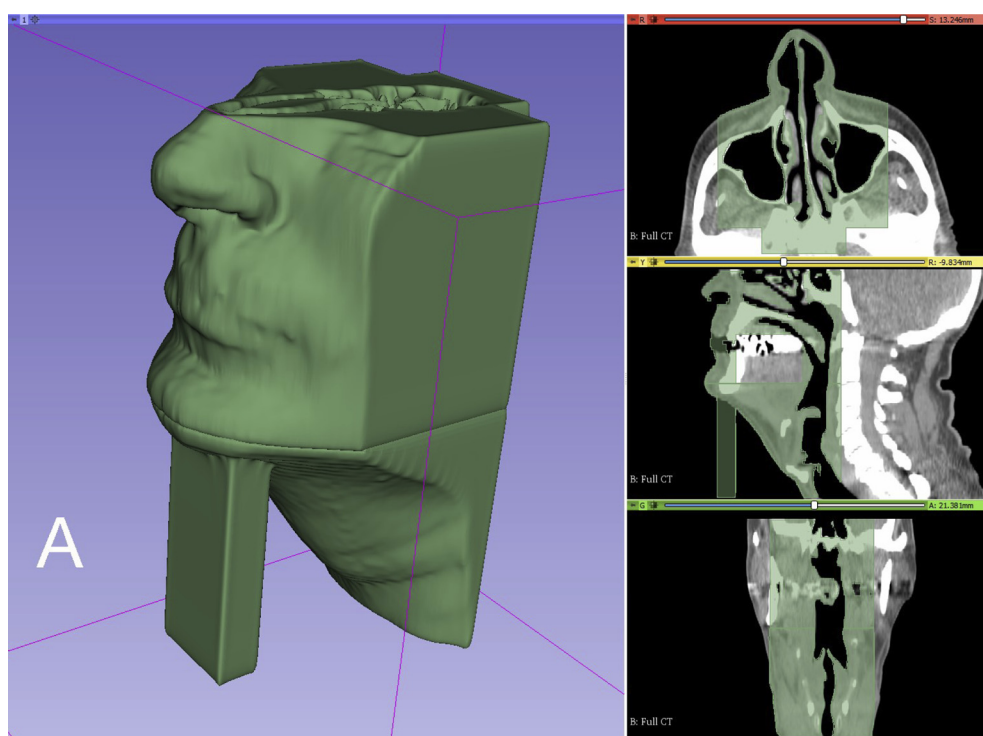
Base computed tomography image with model creation overlay showing airways, hollow region, and supportive stand.
